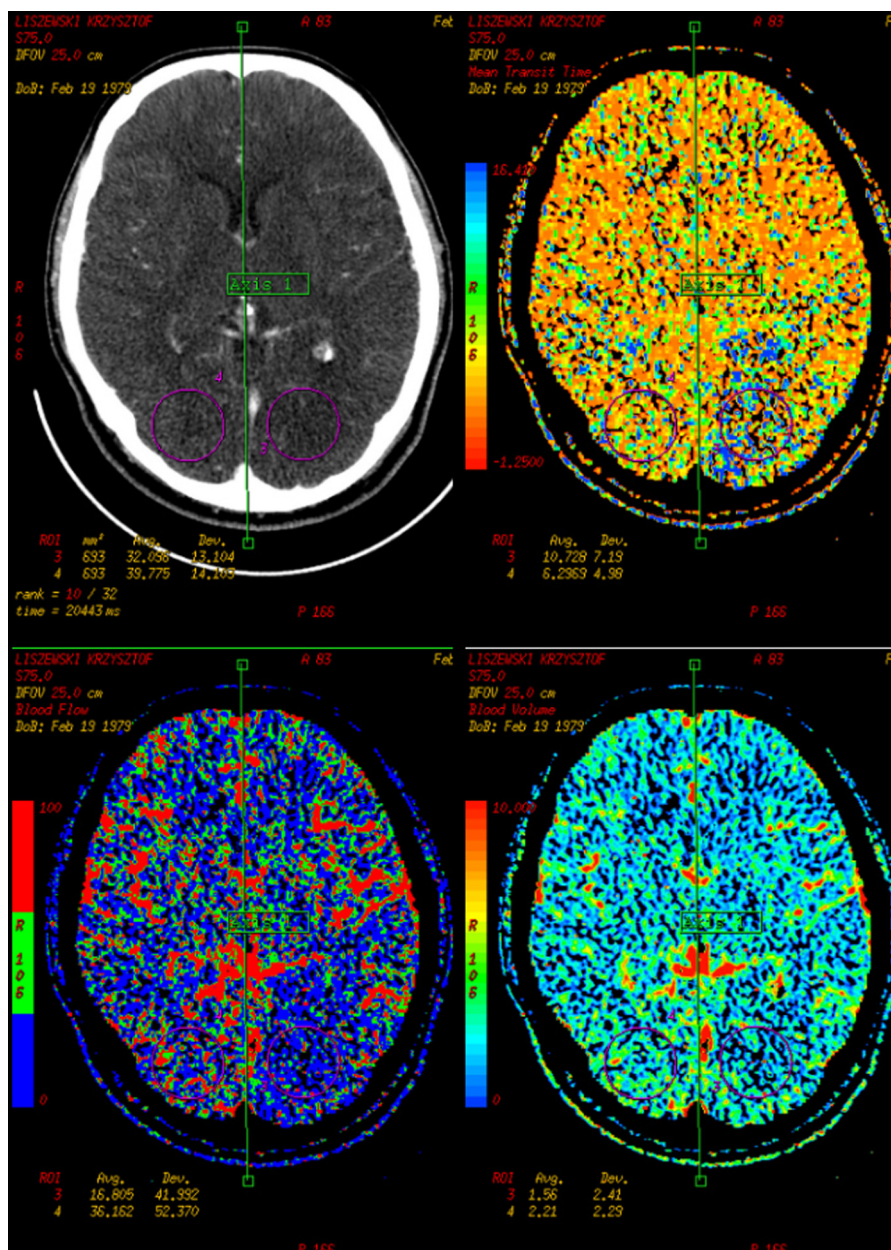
CT perfusion scans. Perfusion abnormalities in left occipital lobe consistent with penumbra: blood flow and blood volume deficits, prolongation of mean transit time.
